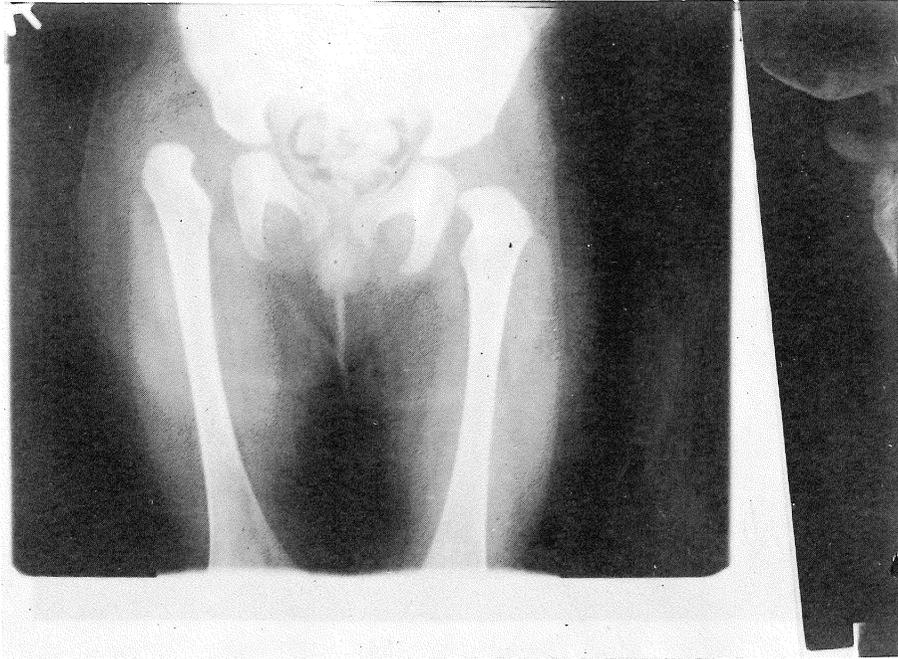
Preoperative radiograph of a one year old girl with right CDH.
